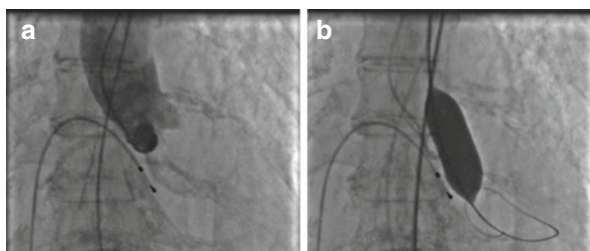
(a) Aortic angiography view of a female with a small aortic annulus. At transthoracic echocardiography mean annulus diameter was 19 mm. (b) Moderately aggressive BAV was performed successfully with the utilization of undersized balloon (18 mm balloon catheter) to reduce the risk of annulus damage
